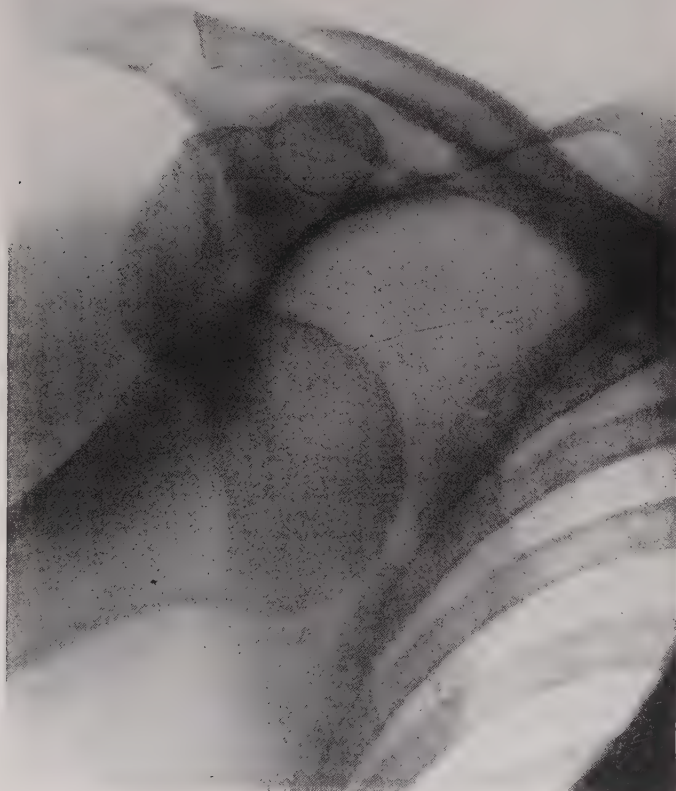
Roentgenogram of subcoracoid dislocation of shoulder. (Fracture Service, M. G. H.)
